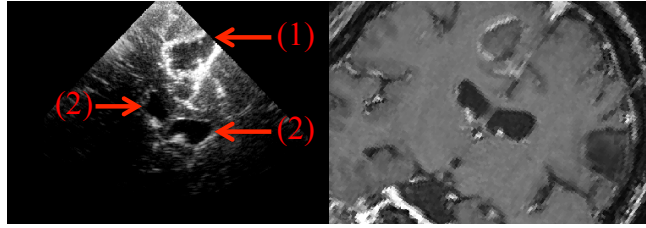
Post-resection US and pre-operative MR images of neurosurgery. (1) and (2) respectively refer to the resection cavity and ventricles. The tumor region in MR does not correspond to the resection cavity in US.
